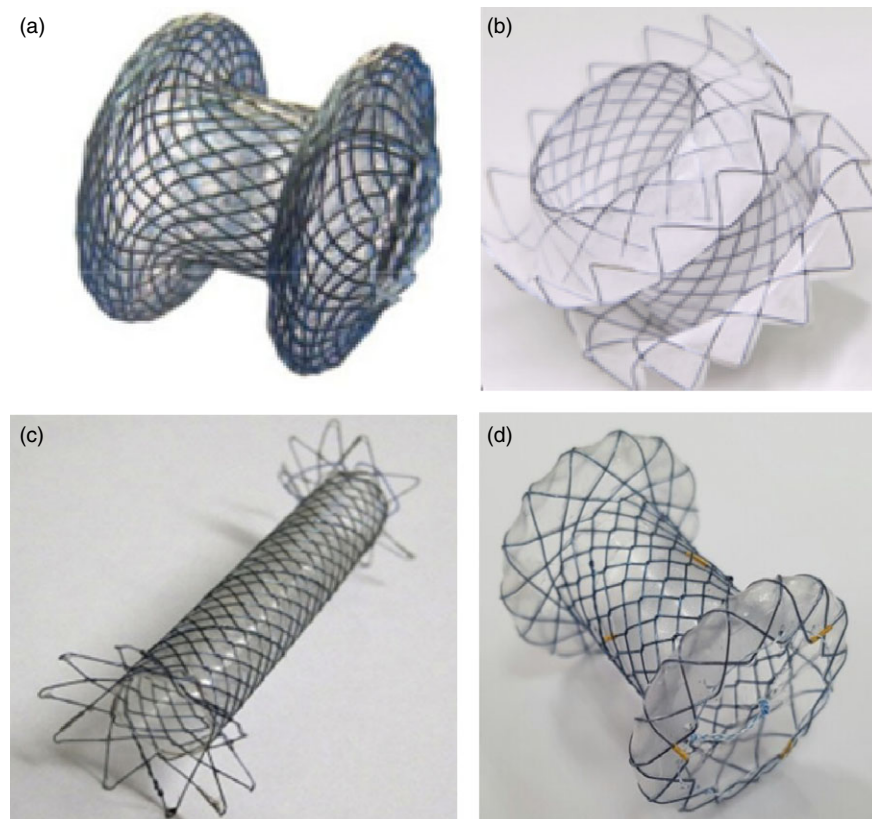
Metal stents for endoscopic ultrasound-guided gallbladder drainage. (a) Fully-covered 10-mm-diameter lumen-apposing stent with dual anchor flanges. (b) Fully-covered metal stent with folding-back wide anchoring flanges for lumen apposition. (c) The flared end of a covered self-expandable metal stent. (d) Biflanged metal stent
